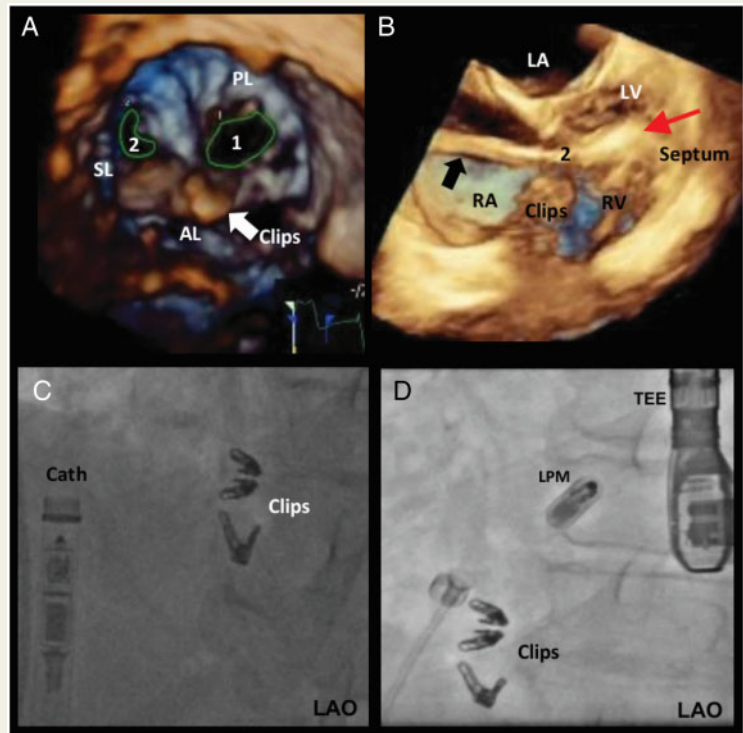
(A) 3D TOE enface view of the tricuspid valve from a right ventricular perspective showing three clips and two neo-orifices: the larger one (NO-1) between AL and PL and the smaller one (2) between AL and SL. (B) 3D TOE adjusted four-chamber view showing the delivery catheter (black arrow) with LPM (red arrow) introduced through the smaller neo-orifice (2) of the tricuspid valve into the RV. (C) LAO X-ray projection prior to insertion of LPM: delivery catheter on the left, three clips in tricuspid position on the right side. (D) LAO X-ray projection shows deployment of the LPM under TOE guidance. 1, large neo-orifice; 2, small neo-orifice; 3D TOE, three-dimensional transoesophageal echocardiography; AL, anterior leaflet; Cath, guiding catheter; LA, left atrium; LAO, left anterior oblique projection; LPM, leadless pacemaker; LV, left ventricle; PL, posterior leaflet; RA, right atrium; RV, right ventricle; SL, septal leaflet; TOE, transoesophageal echocardiography.
